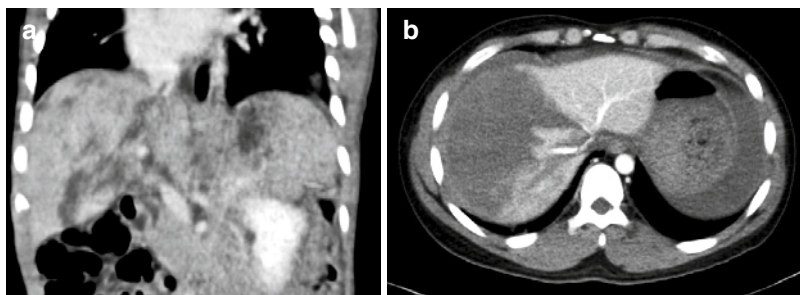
Coronal CT image shows multiple lacerations in the liver and spleen (a). One of the lacerations seen extending up to intrahepatic IVC. An axial CT image (b)
